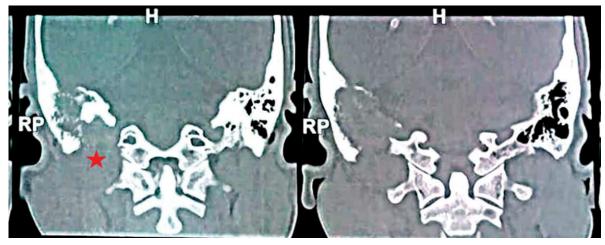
High resolution CT of temporal bone
